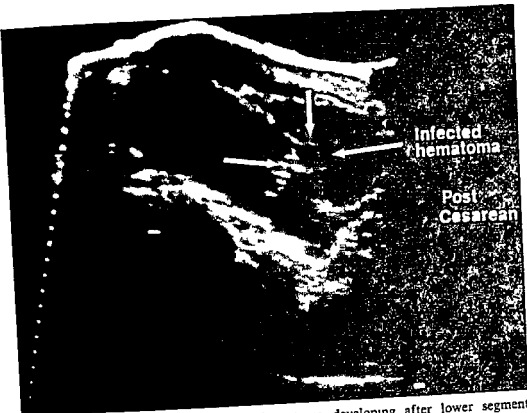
Sonogram demonstrating hematoma developing after lower segment cesarean section (Courtesy Dr R E Woods)
